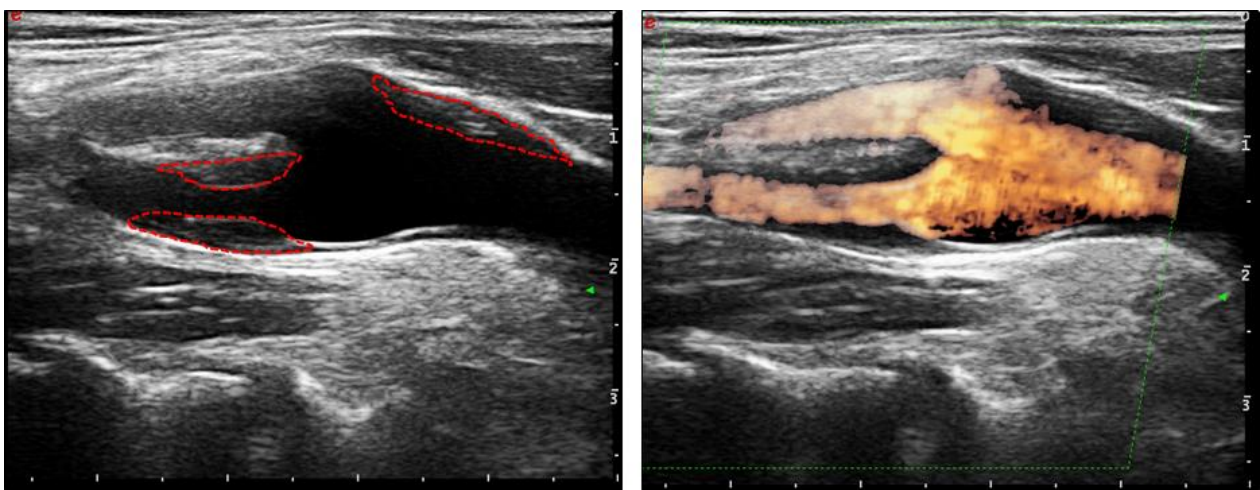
Ultrasonographic images of carotid plaques without (left panel) and with (right panel) color-doppler technique.
